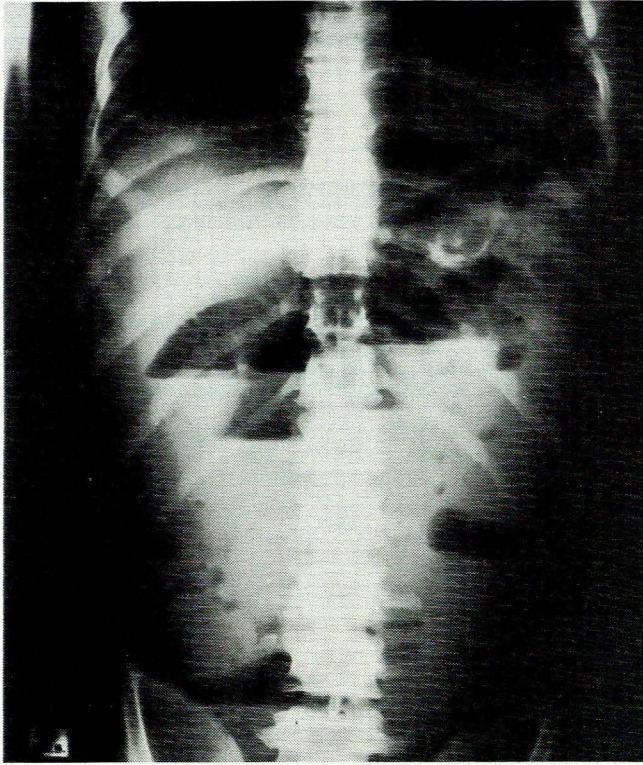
Erect abdominal radiograph showing signs of an incomplete small-bowel obstruction. The incarcerated paraduodenal hernia was not suspected from this radiograph.
